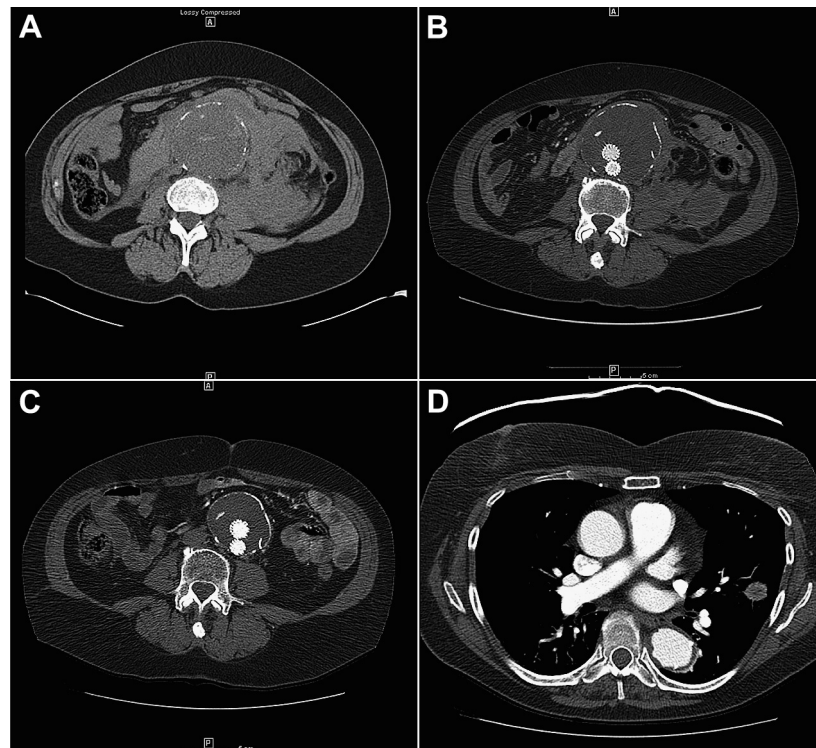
Representative ruptured abdominal aortic aneurysm (rAAA) and follow-up images. A, This 61-year-old female who lived 53 miles from our hospital was woken from sleep by an acute abdominal pain. She was admitted to an outside hospital where this noncontrast computed tomography (CT) angiography revealed an rAAA. She was transferred to our hospital and underwent successful endovascular repair of ruptured abdominal aortic aneurysm (rEVAR). B, Postoperative CT angiography 3 weeks later demonstrated exclusion of the aneurysm sac without endoleak. C, Two-year follow-up CT angiography revealed decreasing sac diameter. D, Two-year follow-up CT angiography of the chest revealed an incidental left upper lobe lung nodule that unfortunately turned out to be biopsy-proven adenocarcinoma. The patient is currently undergoing oncologic workup.
